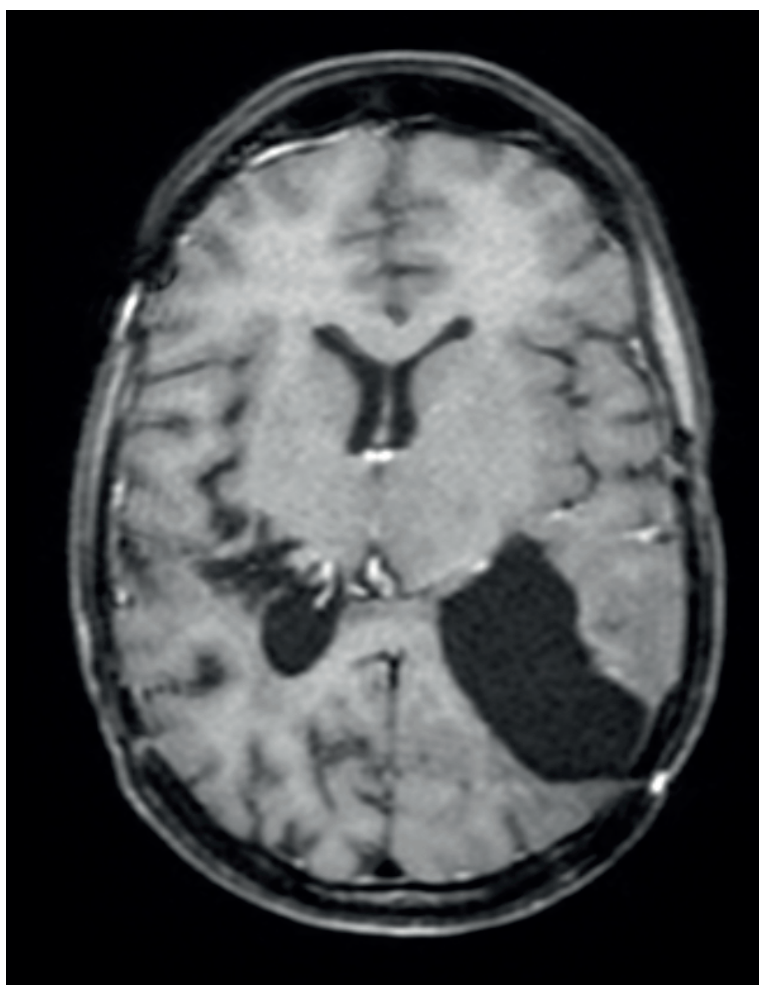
Postoperative MRI with gadolinium 12 months after surgery with no evidence of local recurrence.
